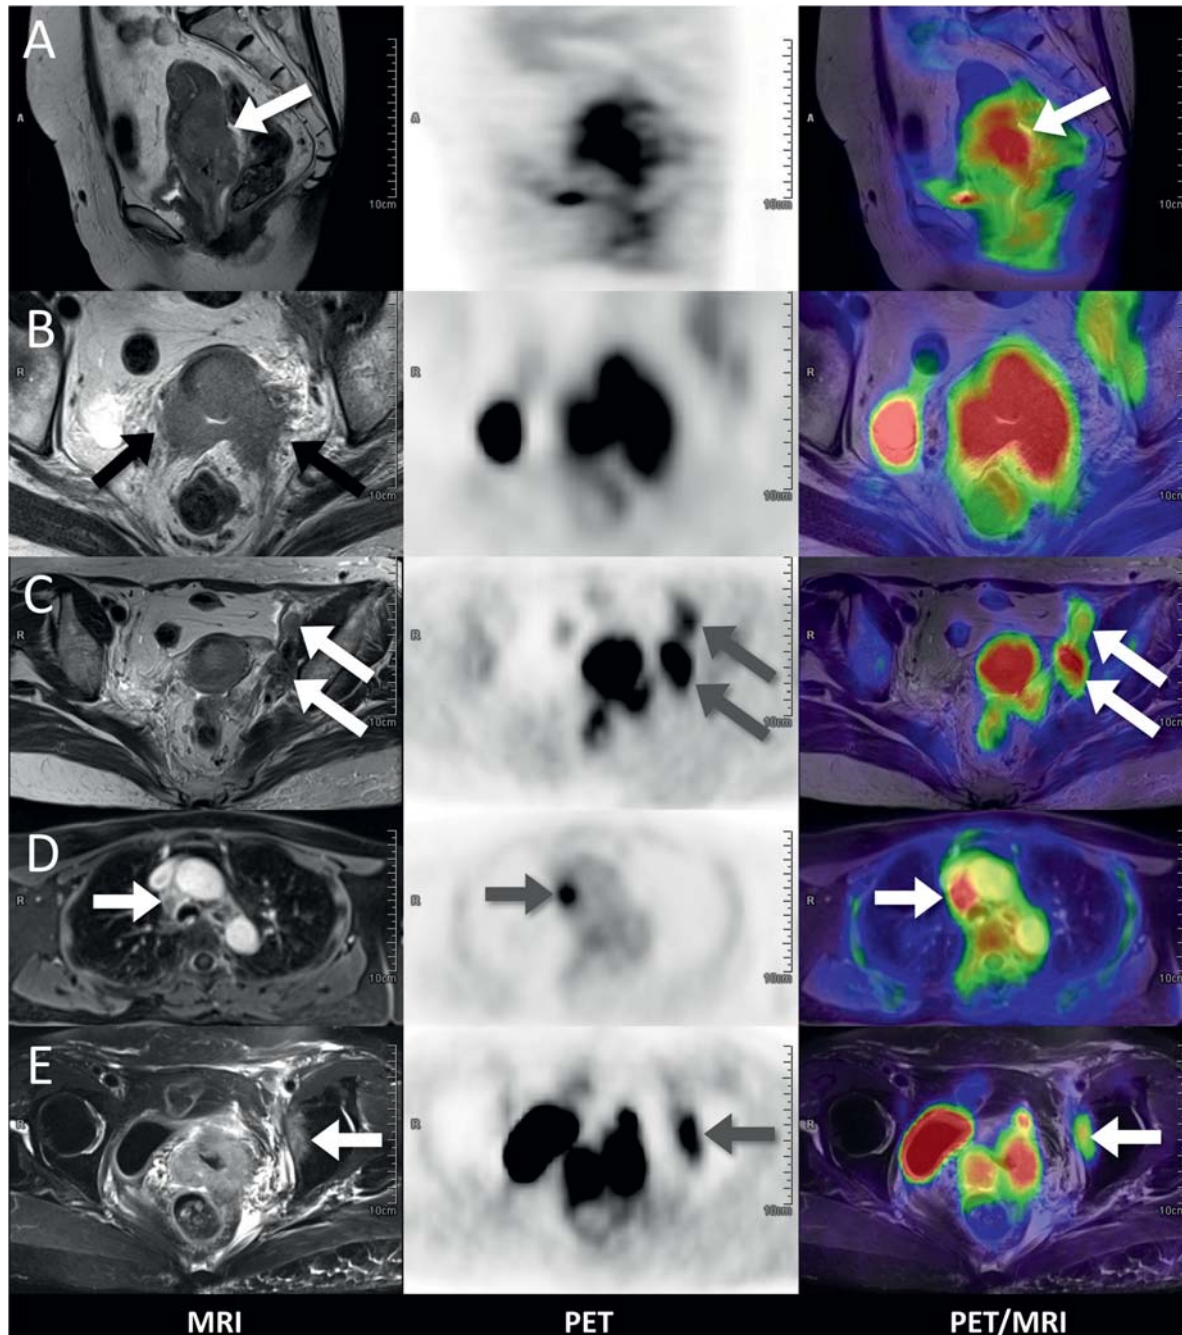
A 70-year-old woman with cervical cancer, squamous cell carcinoma, with multiple lymphadenopathy and bone metastasis, stage IVB. (A) MRI, PET, and PET/MRI showing a large tumor at the uterine cervix (arrows), with high FDG uptake ($SUV_{max} = 9.03$). (B) Axial images show tumor invasion into the bilateral parametrium (arrows). (C) FDG-avid lymph nodes in the left iliac region (arrows). (D) An FDG-avid lymph node in the right mediastinum (arrows). (E) Bone metastasis at the left acetabulum (arrow).
